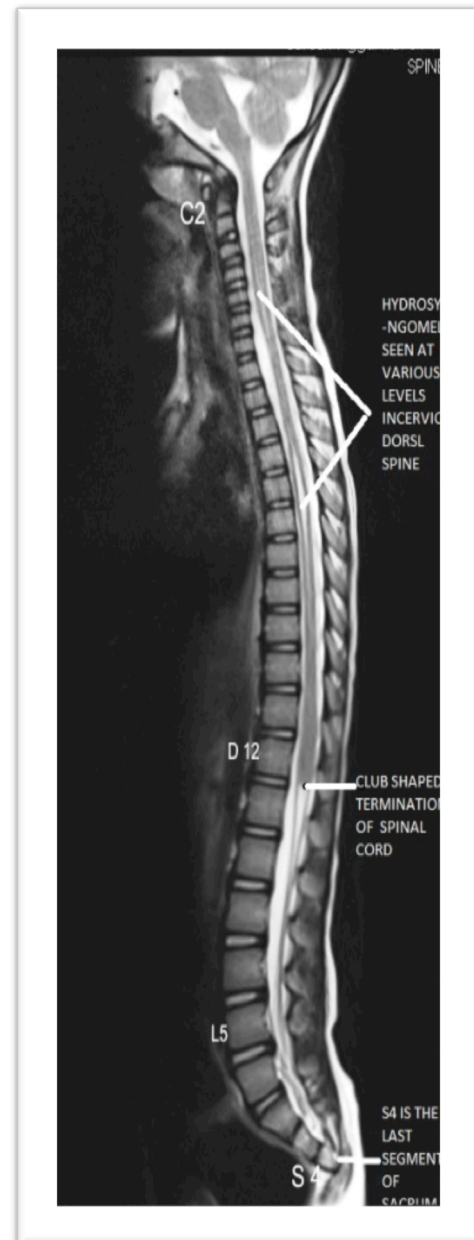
MRI (non contrast image) sagittal section showing club shaped termination of spinal cord with hypersensitivity at various level
